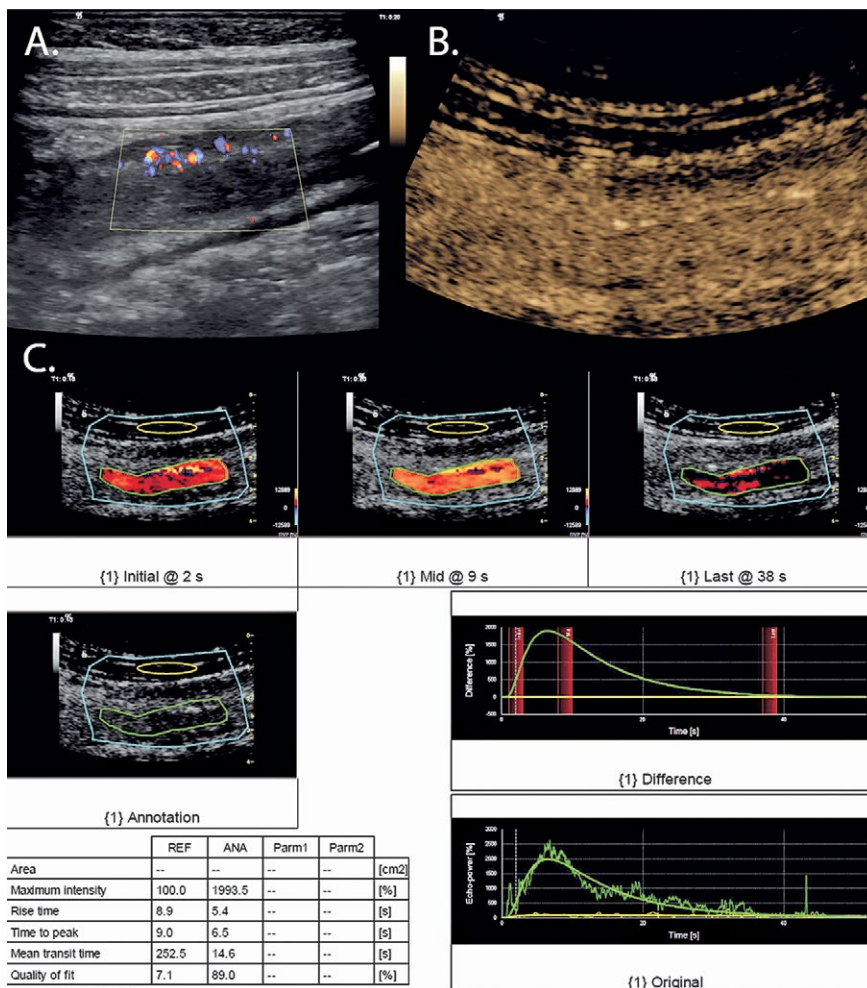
Bowel segment in a patient with moderate activity Crohn's disease: A. color Doppler and B. arterial phase CEUS showing intense vasculature, especially in mucosal and submucosal layers; C. analysis of signal intensity in SonoLiver® with the position of ROI, the reference ROI in the muscle, color maps at different timeframes, the shape of the TIC and the resulting parameters.
